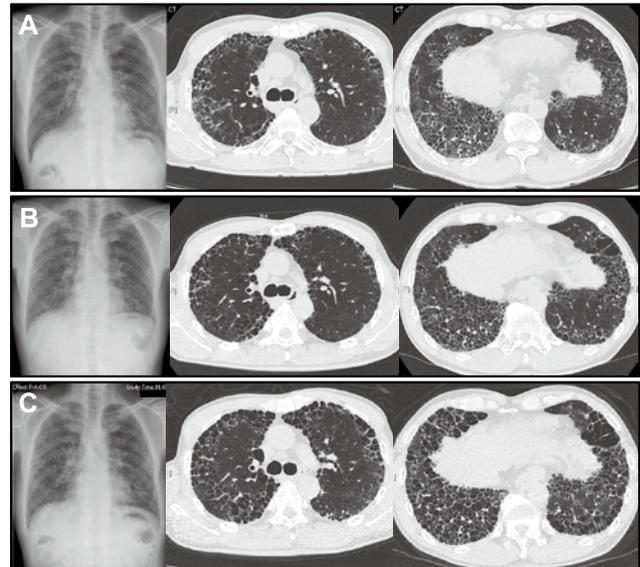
Time course of chest X-ray and HRCT
